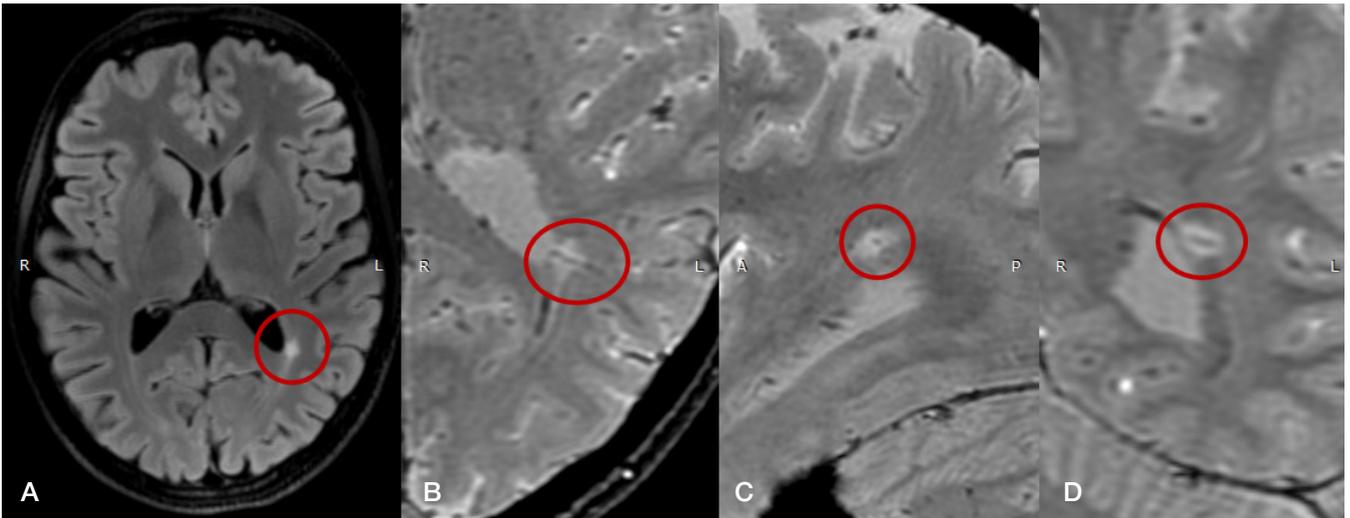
Magnetic resonance images of patient 1. A. A T2-weighted fluid-attenuated inversion recovery (FLAIR) image, the axial plane. The image shows a periventricular lesion in the posterior horn of the left lateral ventricle (marked by the red oval). B. A susceptibility-weighted (SW) image, the axial plane. The image shows a central vein sign in the lesion near the posterior horn of the left ventricle (marked by the red oval). C. A susceptibility-weighted (SW) image; the sagittal plane, the central vein sign appears as a dot in the lesion (marked by the red oval). D. A susceptibility-weighted (SW) image, the coronal plane; the central vein sign appears as a thin line in the same lesion (marked by the red oval)
